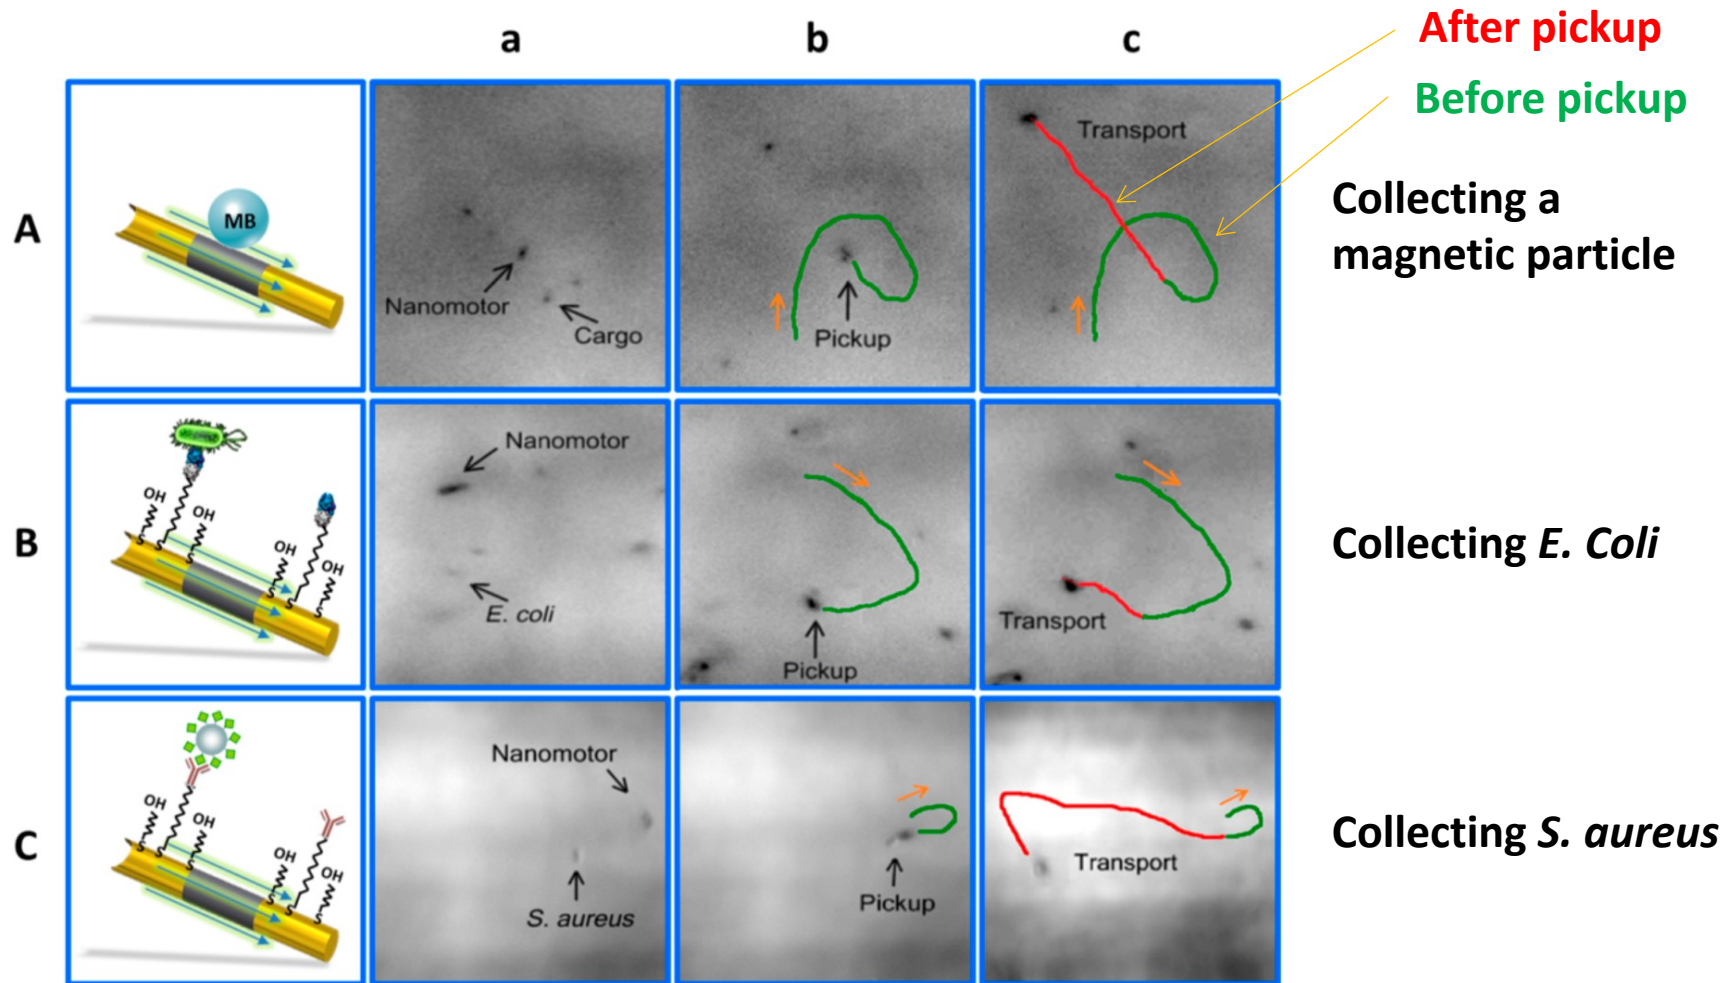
(A) Capture and transport of a $0.89\ \mu\text{m}$ magnetic bead by an ultrasound-propelled Au/Ni/Au unmodified nanomotor approaching (a), capturing (b), and transporting (c) the magnetic particle. (B) Capture and transport of *E. coli* bacteria by a lectin-modified ultrasound-propelled nanomotor: (a) approaching, (b) pickup, and (c) transport the *E. coli* bacteria. (C) Capture and transport of *S. Aureus* bacteria by a Con A-modified ultrasound-propelled nanomotor: (a) approaching, (b) pickup, and (c) transport the *S. Aureus* bacteria. Conditions: media, deionized water (A) and PBS (pH 7.0) solutions (B and C); ultrasound field, 6 V and 2.51 MHz.
